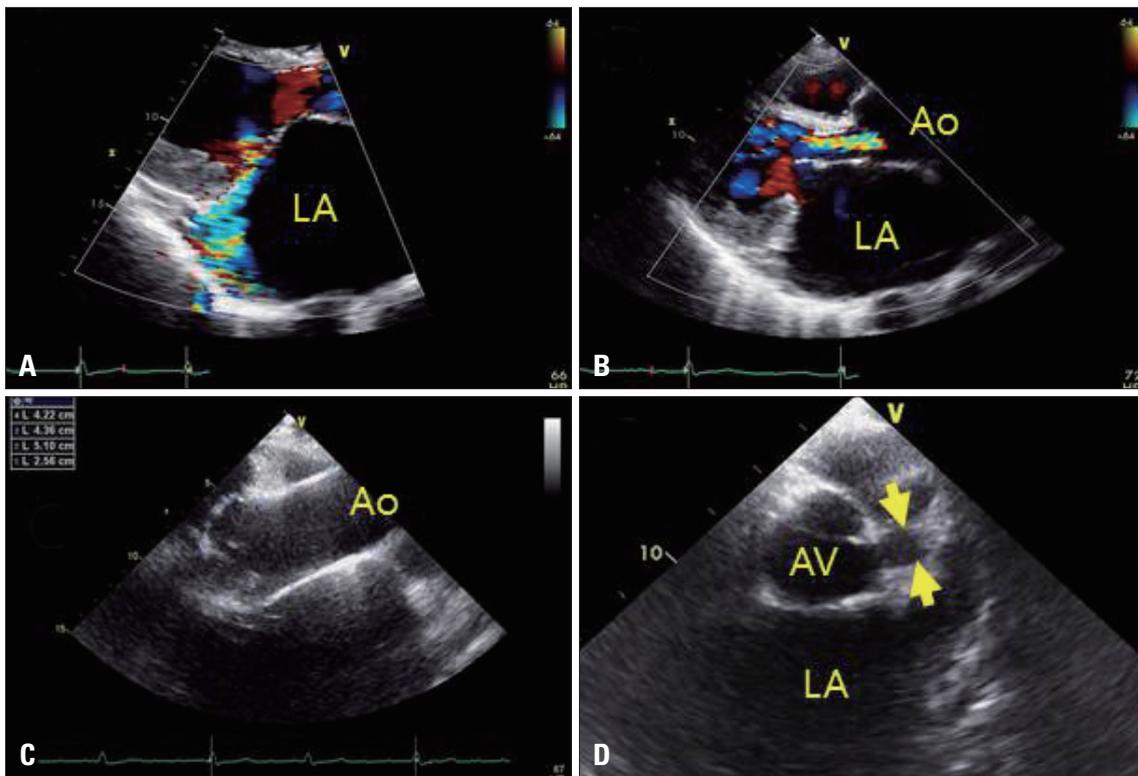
Transthoracic echocardiography. A: Eccentric and severe mitral regurgitation is observed on the parasternal long-axis view. B: Moderate aortic regurgitation is shown on the parasternal long-axis view. The size of the vena contracta is approximately 6 mm. C: The modified parasternal long-axis view shows annuloaortic ectasia. D: At the aortic valve level of the parasternal short-axis view, 15-mm dilatation of the left main coronary artery (arrows) is seen. LA: left atrium, Ao: aorta, AV: aortic valve.
